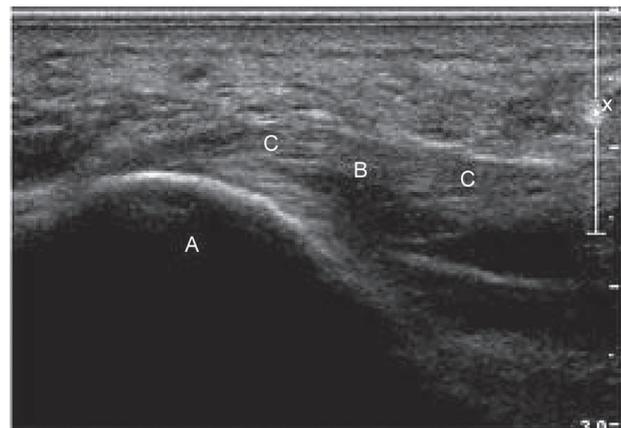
Longitudinal ultrasound image of the left hindfoot with a small deep surface partial-thickness tear. A indicates the calcaneus; B, partial-thickness tear in the plantar fascia; and C, normal plantar fascia without tear.
